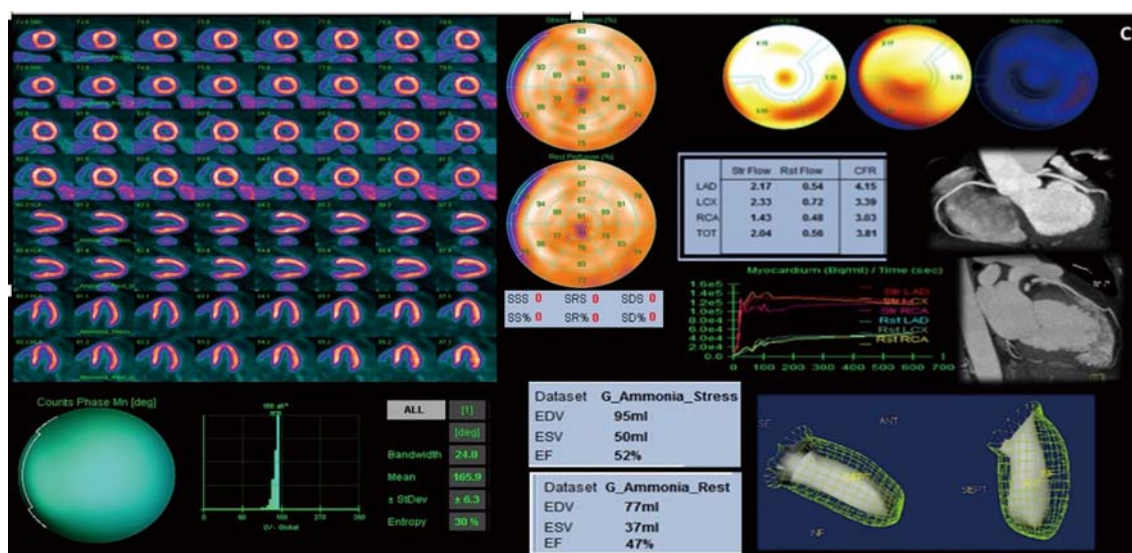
^{13}N -ammonia PET/CT. Normal myocardial perfusion study. Splash and polar maps with normal uptake. SDS=0. Normal synchrony. Adequate systolic functions with normal movement of all walls and segments. Normal flow quantitation: Rest MBF, 0.56; stress MBF, 2.04; MFR, 3.81. CCTA without obstructive lesions.
